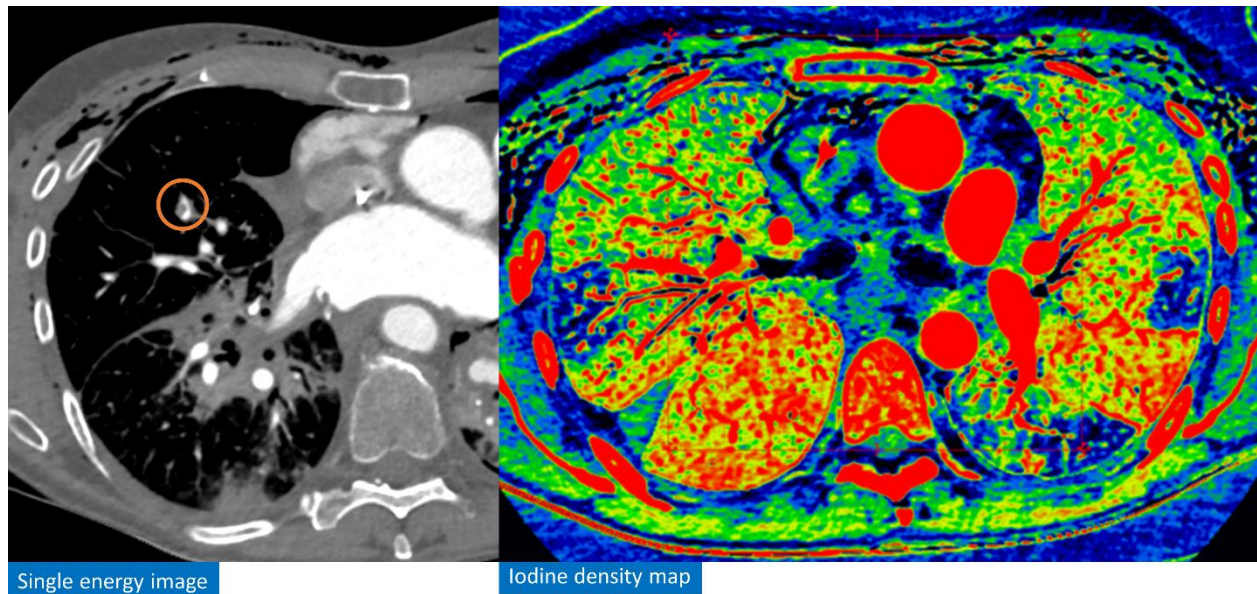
Pulmonary CTA in a patient with post lung transplantation (day 5) dyspnea. While HU images depicted right middle lobe sub segmental pulmonary embolism (orange circle), iodine basis images (“iodine density maps”) representing iodine distribution (blue, no iodine, red maximum iodine concentration) help diagnose multiple bilateral peripheral perfusion defects throughout the lungs (not all defects are shown in the Figure), consistent with additional occlusive pulmonary emboli.
